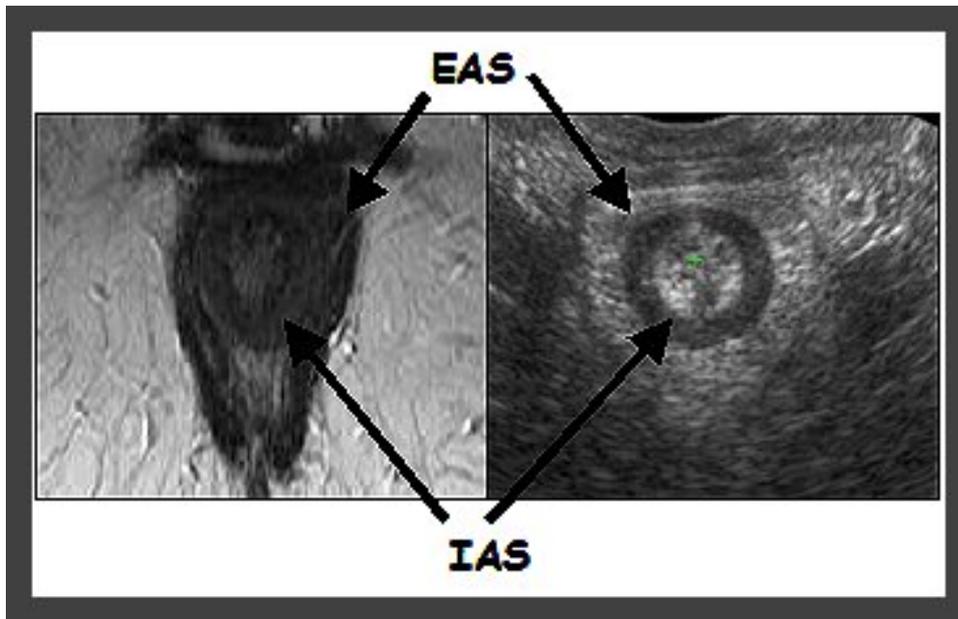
MRI (left) and 3DUS (right) images with external anal sphincter (EAS) and internal anal sphincter (IAS) identified on the images from the same subject.
